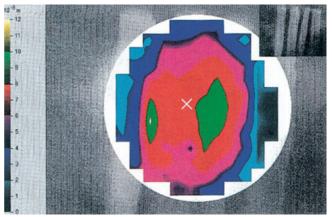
Laser Doppler scanning vibrometry of cartilage palisades in the flat position. The arrangement of the cartilage is shown in the black-and-white inset. The peak amplitude of membrane vibration (yellow-green) between two cartilage strips slightly farther apart is greater than that of the cartilage. The frequency curve was plotted at the white cursor (see Fig. 2.18).
